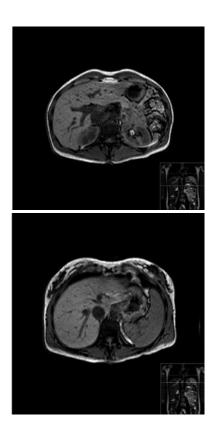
Magnetic resonance imaging of the liver at 2 year follow up demonstrating complete resolution of liver lesions.
